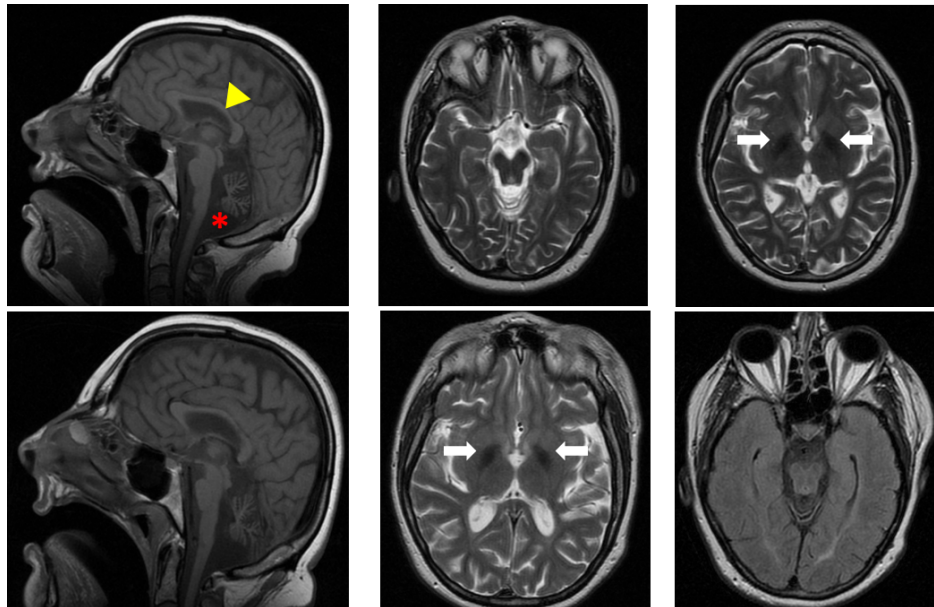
Radiological findings of the SFPQ patient. Top panel: MRI studies at the age of 36 years. Sagittal T1 and axial T2 studies reveal severe cerebellar and vermian atrophy, with brainstem hypotrophy (red asterisk) and thinning of the corpus callosum (yellow triangle). In the supratentorial area, periventricular white matter signal abnormalities are evident. Symmetric hypointensity of the globus pallidus is also present (white arrows). Bottom panel: At the age of 40 years abnormal white matter signal, cerebellar and vermian atrophy and brainstem hypotrophy is documented in T1 axial images. Hypointensity of globus pallidus in T2 and inversion recovery fast spin-echo FLAIR sequences is also detected (modified from Efthymiou and Gordon, 2020).
